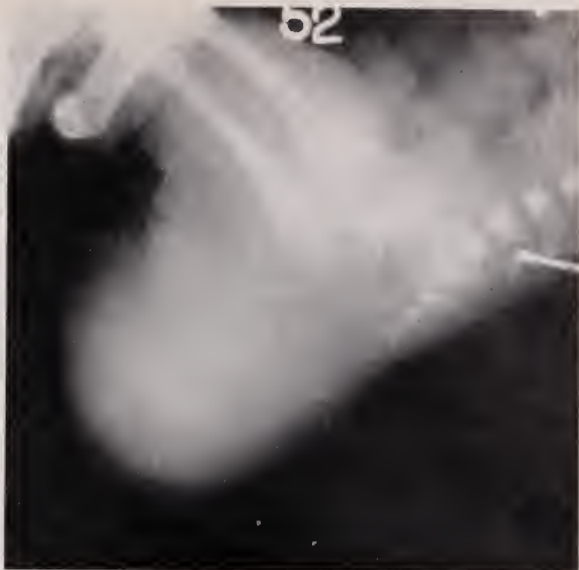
X-ray photograph of the tumor from the lateral surface showing the absence of dense materials within. X $\frac{1}{3}$.
